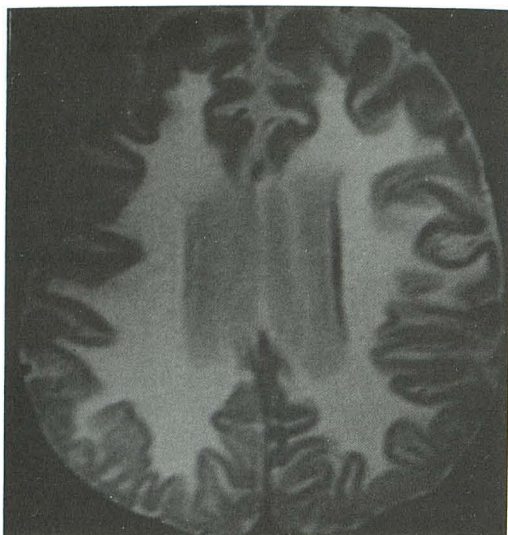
Axial T2-weighted MR image (2000/80) in 11-year-old boy with ALD shows diffused, abnormally increased signal intensity in white matter and associated atrophy. At autopsy, this patient also had atrophy of the spinal cord.
